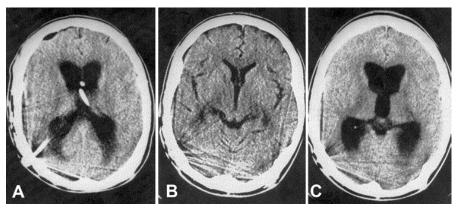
Case 1. A: A CT scan obtained on postoperative Day 5 showing ventriculomegaly. B and C: CT scans showing resolution of the ventriculomegaly after neck wrapping (B) and recurrence of ventriculomegaly when the neck wrap is removed (C).
